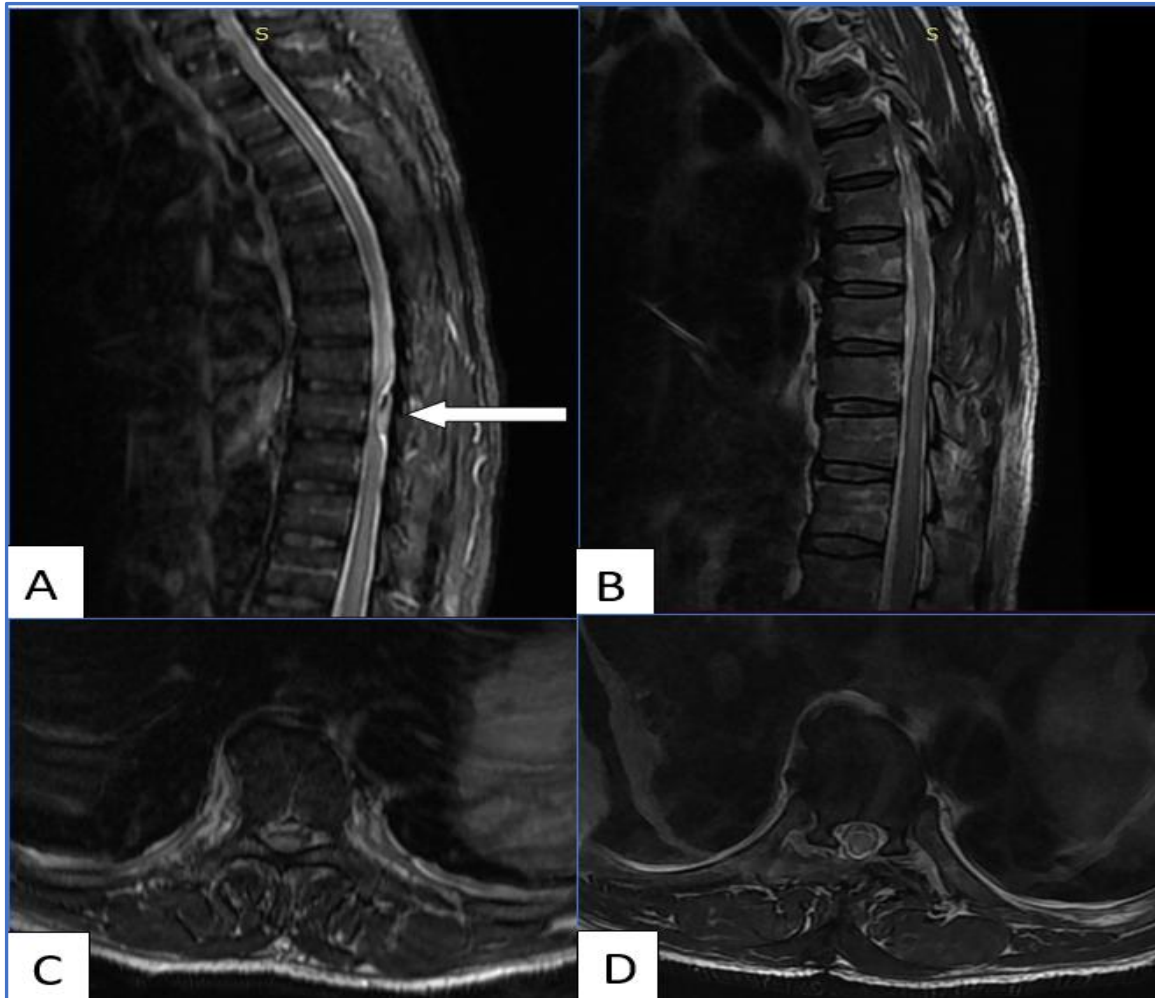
Magnetic Resonance Imaging (MRI) scan (T2-weighted) shows the dorsally located haematoma at the T9 vertebral level with cord compression, before (A and C) and three months after surgery (B and D).
